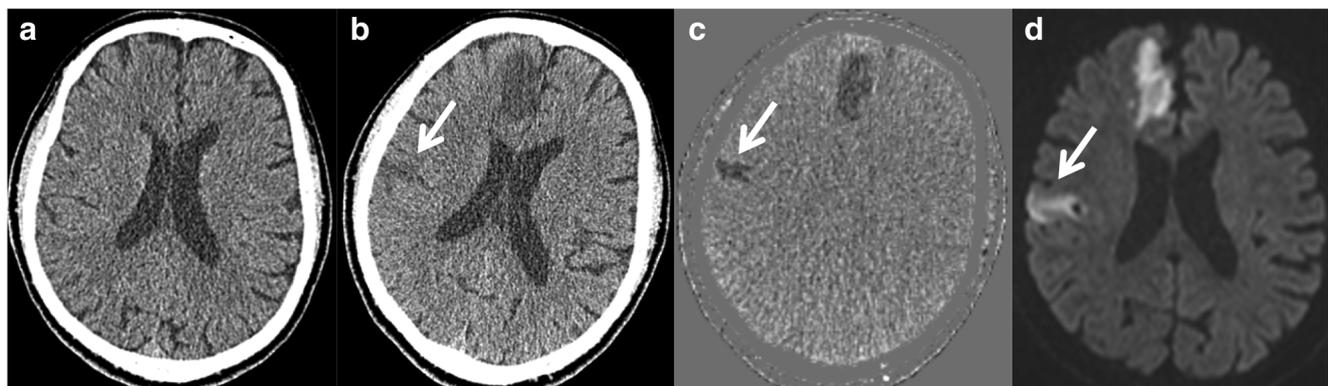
A case of a 72-year-old male with a fresh infarct in the right frontal lobe (arrow). From the left the (a) previous CT, (b) current CT, (c) TS CT and (d) DWI image ($B = 1000$) are shown. The lesion was correctly
